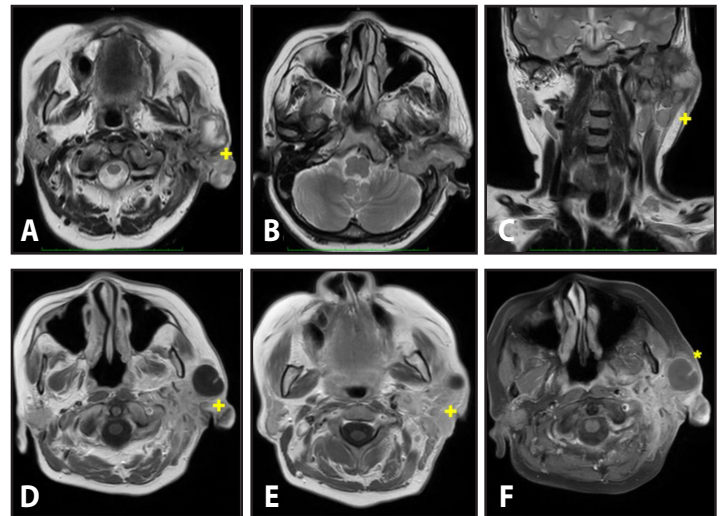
Magnetic Resonance Imaging; A., B., D., E., F., axial and C., coronal sections showing areas of hyperintensity signal on DWI in the left mastoid region with D.-F., T1 hypo intensity and A.-C., mild T2 hyperintensity signals and enhancement on post contrast administration. (*) Multiple, heterogeneous fluid collections are seen in the left infraauricular region, with the largest measuring 2.7 x 2.2 x 2.0 cm. (+) These exhibit T1WI hypointense signal, T2/DWI hyperintense signal and rim enhancement post contrast administration.
